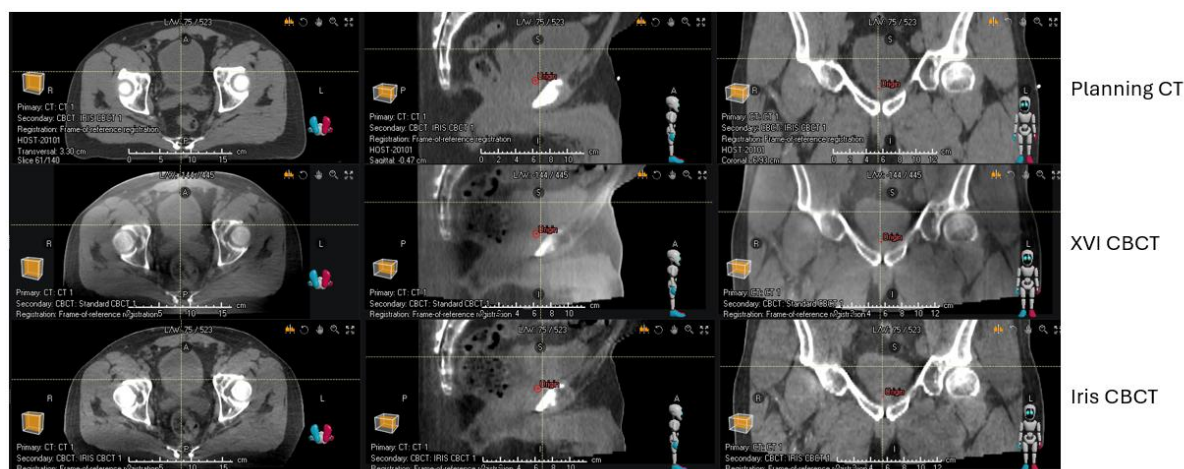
Comparison of planning CT scan (top row), standard XVI pelvis CBCT (middle row) and Iris AI-enhanced pelvis CBCT (bottom row) for a male patient undergoing bladder radiotherapy.
